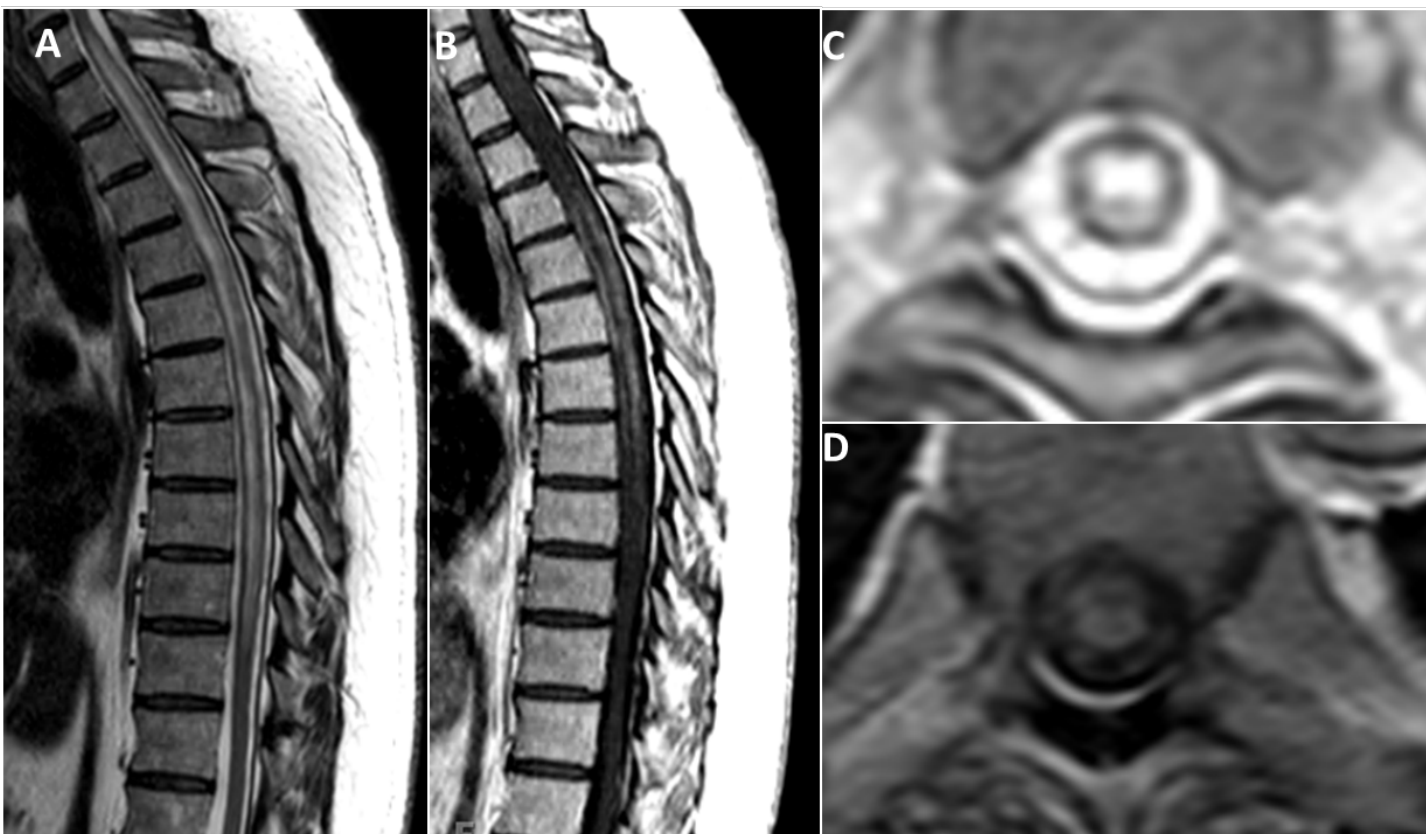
MRI of inflammatory myelopathy; A: sagittal T2, B: sagittal T1+ gad, C: axial T2, D: axial T1+ gad
